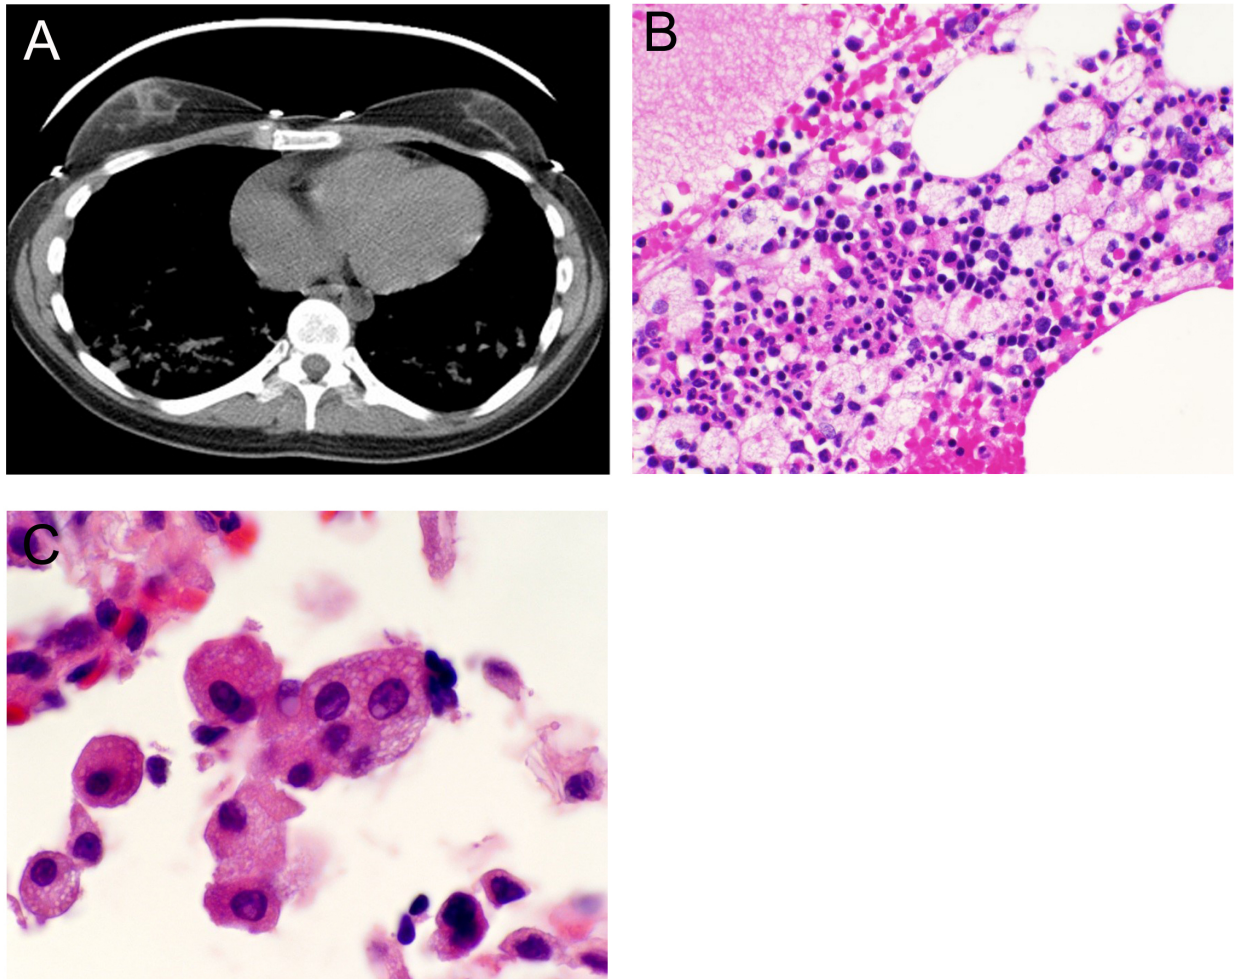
A. Chest computed tomography showed multiple bilateral lung nodules. B. Bone marrow examination demonstrated collection of foamy, vacuolated histiocytes characteristic of NPD. C. Endoscopic transbronchial biopsy showed lung tissue with intra-alveolar collection of foamy, vacuolated histiocytes consistent with involvement by NPD..
